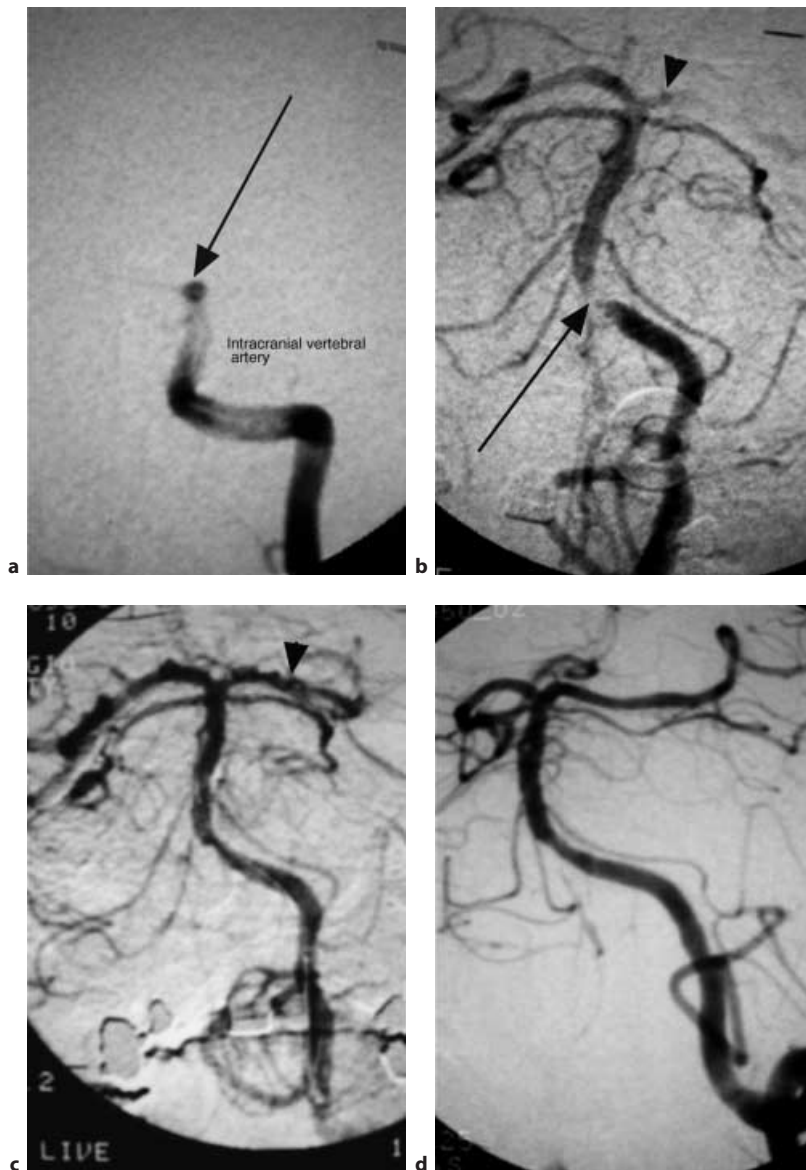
a A 66-year-old man presenting semicomatose, no tumor or hemorrhage on initial CT (not shown), with selective left vertebral artery injection showing complete distal vertebral artery occlusion (arrow). The right vertebral artery was nondominant and carotid injection confirmed inadequate posterior communicating arteries, without significant filling of the distal basilar artery. b, c After urokinase, local pulsed infusion shows recanalization of vertebral and basilar arteries and an uncovered stenosis of the distal left vertebral artery extending to the vertebrobasilar junction (arrow). The left posterior cerebral artery does not fill (arrowhead) and no abnormal anatomy had been shown on the carotid study. A catheter (c) passes through the basilar artery for administration of more urokinase to thrombus in the posterior cerebral artery (arrowhead), which is now patent but with some remaining irregularity, indicating some persistent clot (treated with more urokinase). d Final images after angioplasty of the focal stenosis with reconstitution of a good luminal diameter, no dissection encroaching on the lumen, and good distal flow. The posterior cerebral artery is now free of thrombus. Following this excellent angiographic result, the patient made a good clinical recovery, returning to independence with no major deficit
